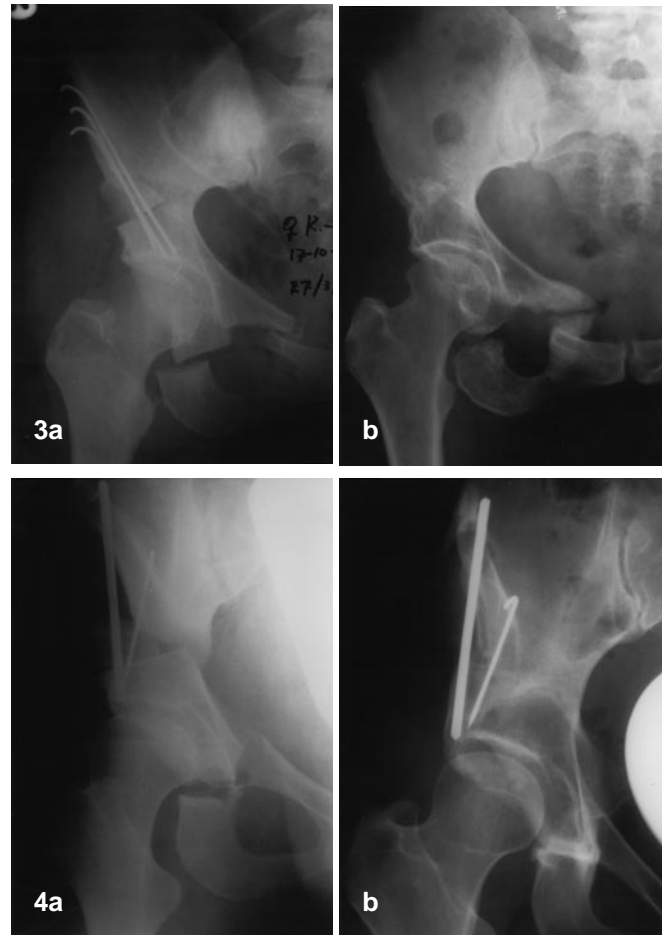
a Anteroposterior radiograph taken directly after triple osteotomy and pubic osteotomy from the medial approach. Part of the pubic bone is still attached to the acetabular fragment. b fourteen years postoperatively there is a pseudo-arthrosis of the pubic bone (and of the ischium)
